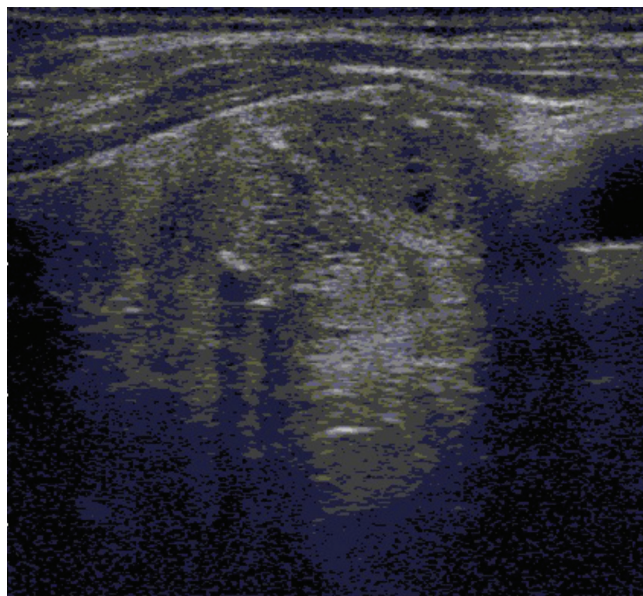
Thyroid ultrasound revealed a 14x14x22 mm nodule with a mixed echo pattern, rough calcification foci and cystic-necrotic areas in the left lobe lower pole. Fine needle aspiration biopsy of this nodule complied with benign follicular nodule.
